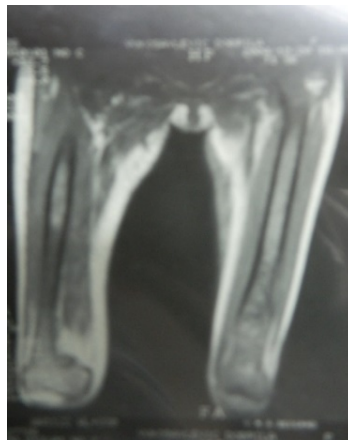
MRI of the femur: Erlenmeyer flask deformity of both femurs
